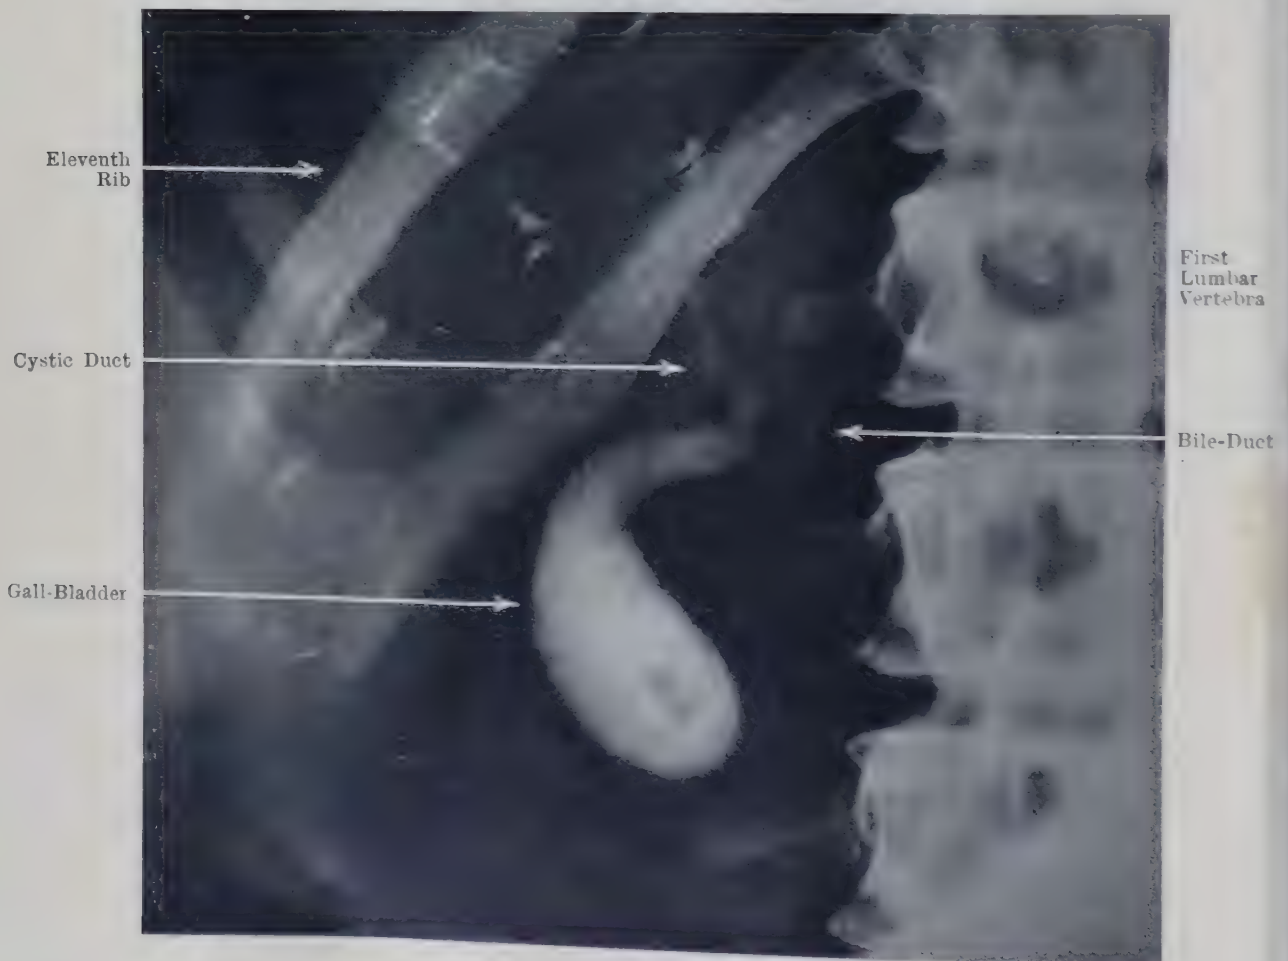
RADIOGRAPH (FEMALE ADULT), AFTER ADMINISTRATION OF S.T.I.P.P. (see pp. 667, 1556), SHOWING POSITION OF THE GALL-BLADDER AND THE CYSTIC DUCT THE BILE-DUCT ALSO IS FAINTLY SEEN.
